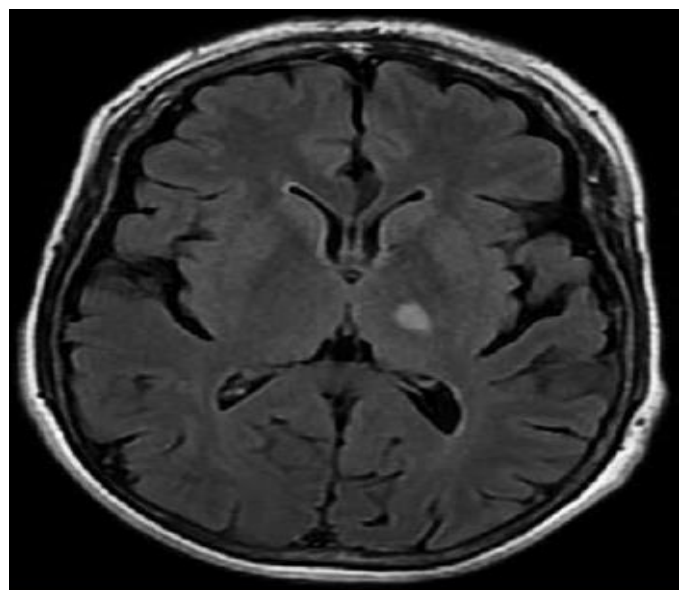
Magnetic resonance imaging, DWI/FLAIR sequence, axial section, confirming lacunar infarction that encompasses the genu of the internal capsule and thalamus on the left side. (2)
